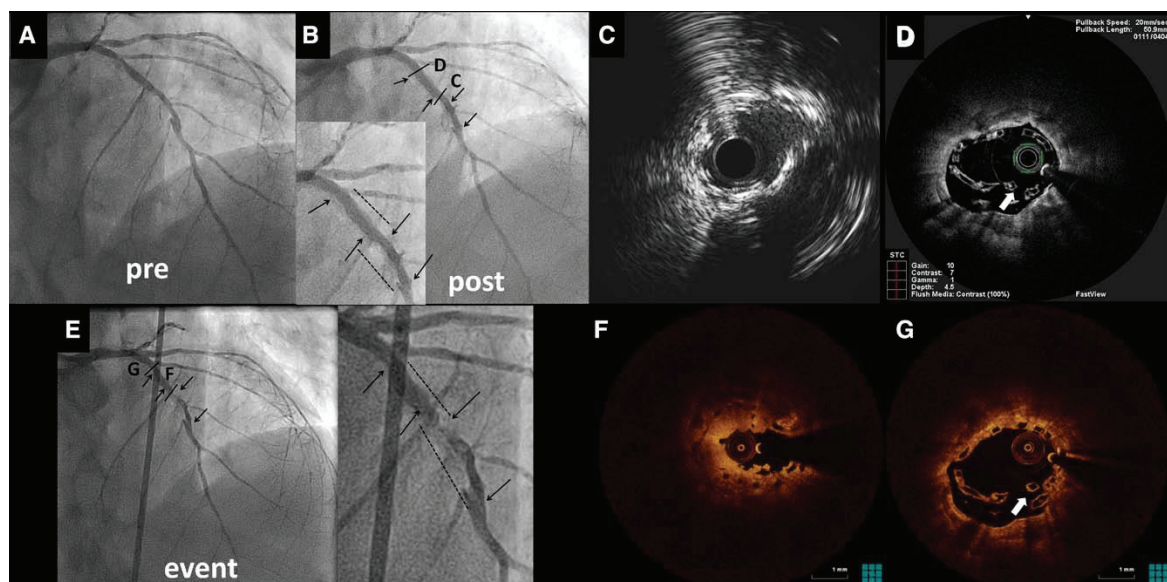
Late scaffold thrombosis after dual antiplatelet therapy discontinuation in overlapping bioresorbable vascular scaffold (BVS) with underexpansion. Overlapping BVS implantation in a diffuse calcified left anterior descending artery lesion (A), with acceptable angiographic result (B), but underexpansion by intravascular ultrasound (C), and scaffold fracture at the proximal edge by optical coherence tomography (OCT; D), possibly because of deep catheter intubation. The patient experienced late thrombosis 161 days post implantation (E), 2 days after aspirin and clopidogrel discontinuation. OCT shows thrombosis mainly at the overlap region, with low minimal scaffold area (4.21 mm^2 ; F), whereas the fracture site remains free of thrombus (G).
